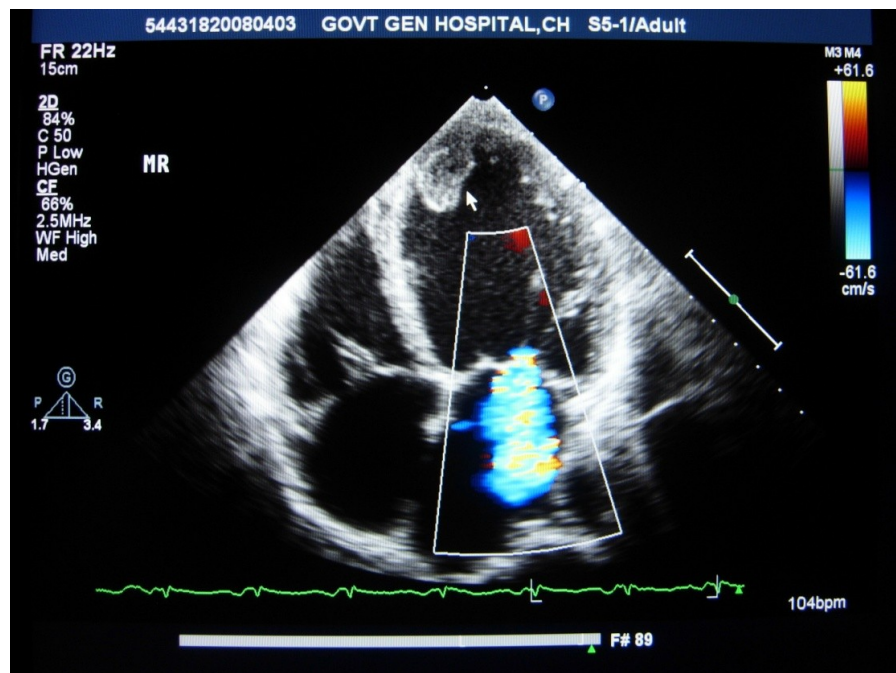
2D Echo (apical 4 chamber view) demonstrating Mitral Regurgitation (mod MR 2+). Thrombus is seen in the LV apex (arrow)
